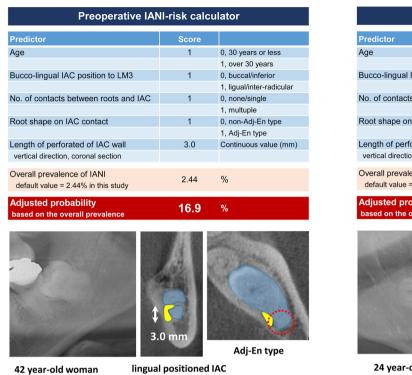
A preoperative inferior alveolar injury (IANI)-risk calculator. The left panel shows an example of a 42-year-old woman. CBCT images include the lingually positioned inferior alveolar canal (IAC) in contact with multiple roots, Adj-En (adjacent to the enlarged part of the root) type of relationship between the root shape and IAC contact, then the perforated IAC wall of 3.0 mm in length. The IANI probability adjusted by an overall prevalence of 2.44% in this study accounts for 16.9%. The right panel shows an example of a 24-year-old man. CBCT images include the buccally positioned IAC in contact with the single root, the non-Adj-En type, and the perforated IAC
